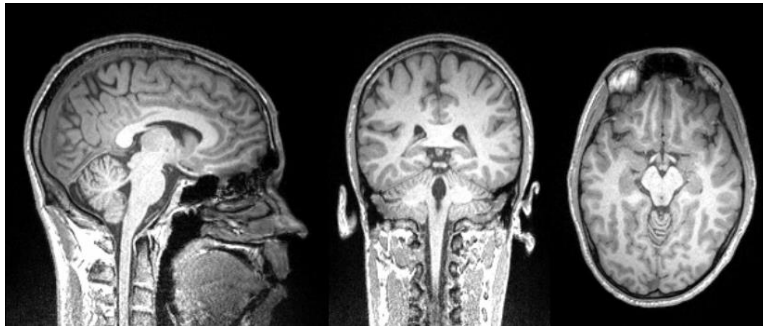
T1 MRI imaging. *Sagittal plane (left), coronal plane (center) and horizontal plane (right) of the human brain.*
